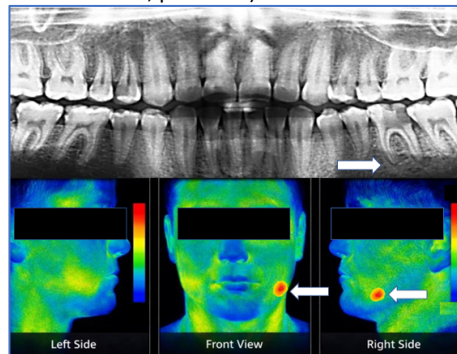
Panoramic radiograph with a thermal pattern suggestive of periapical inflammation.
